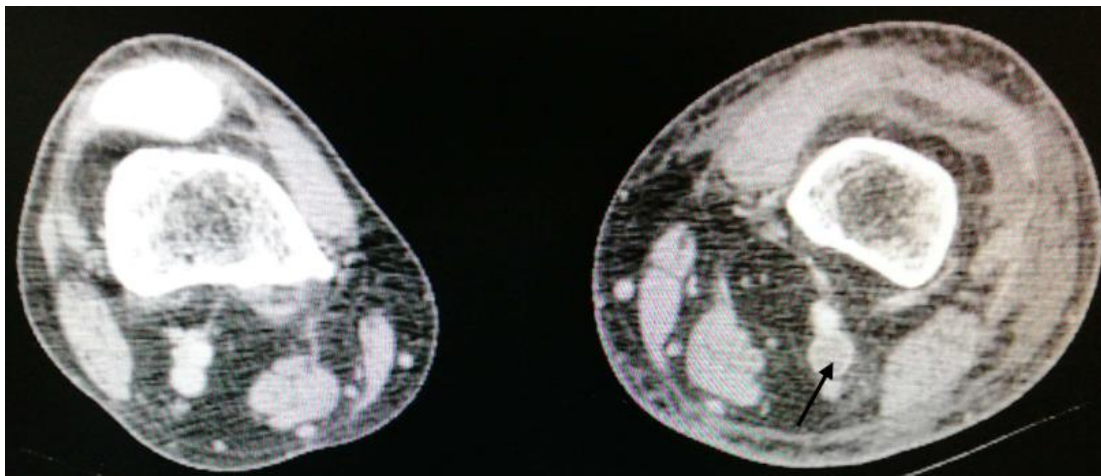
Axial indirect CT venography showing left popliteal vein DVT (arrow)
